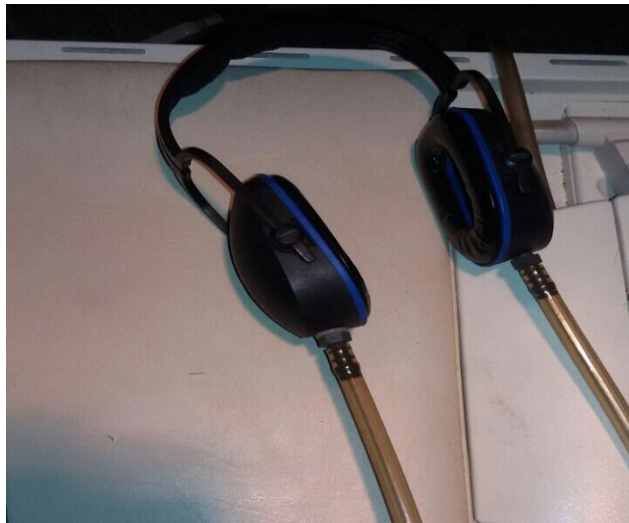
EAR PLUG SIEMENS MRI MACHINE (GERMANY), (ALRIBAT UNIVERSITY HOSPITAL).
